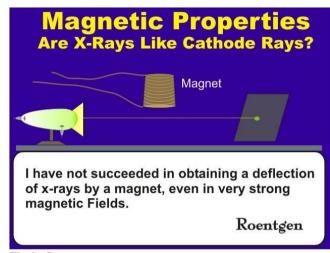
Cathode rays within a tube can be deflected with a magnet, but not x-rays emitted from a tube.
